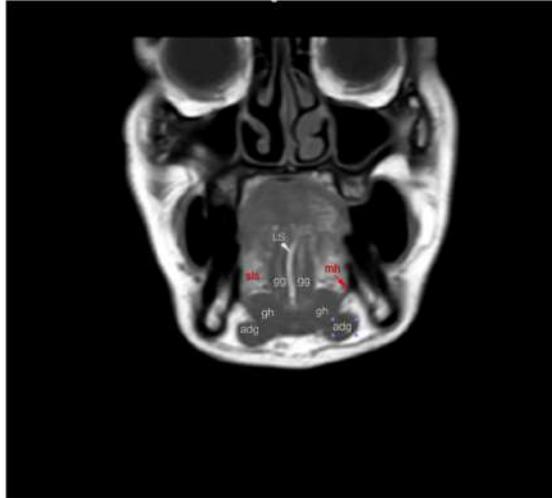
Anatomy: Coronal T1W MRI shows genioglossus (gg) muscles delineated as vertical pillar-like para-midline structures. The geniohyoid (gh) muscles appear subtly wider than and below the genioglossus muscles. The sublingual spaces (sls) and lingual septum (LS) show high signal intensity on T1W images. Mylohyoid (mh) separates oral cavity from the floor of mouth which contains the anterior belly of Digastric (Adg) muscles.
